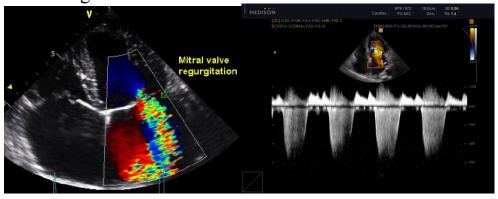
Doppler-echocardiogram. Mitral valve insufficiency and ventricular dysfunction.
